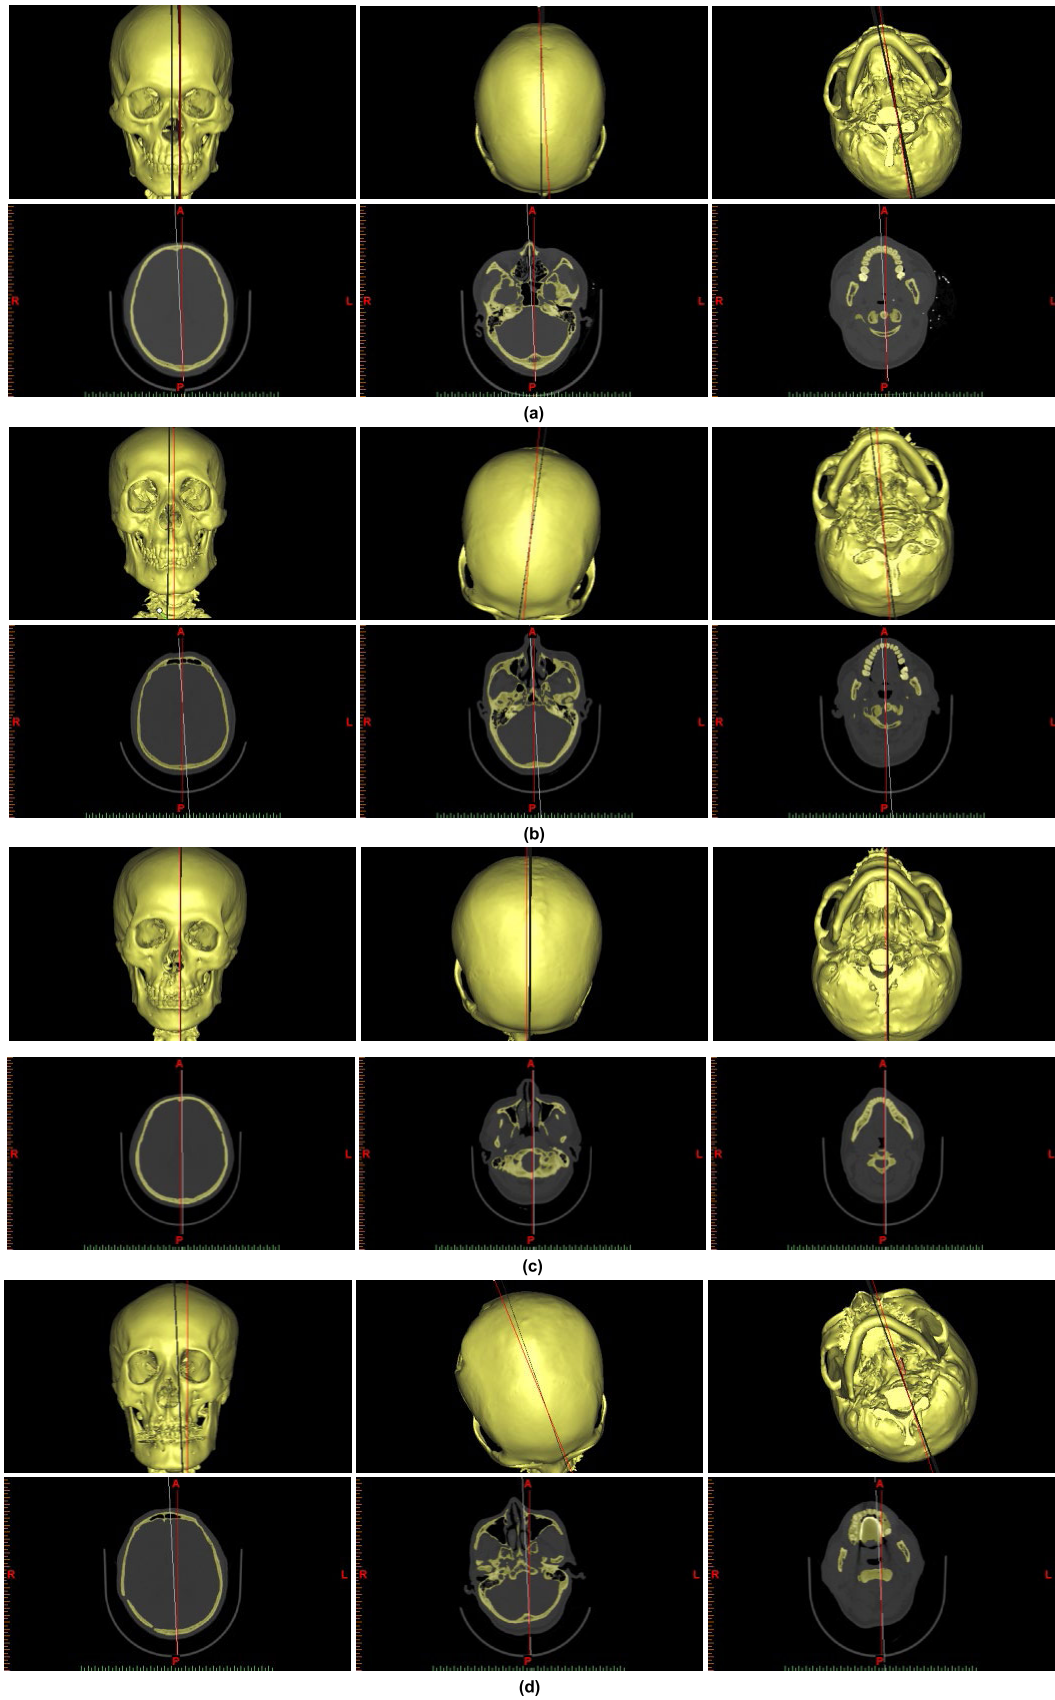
The comparison results of the 10 patients' head CT image datasets of doctor's manual method and this method: (a-i) figures are the result of the 10 patients' head CT image datasets.
